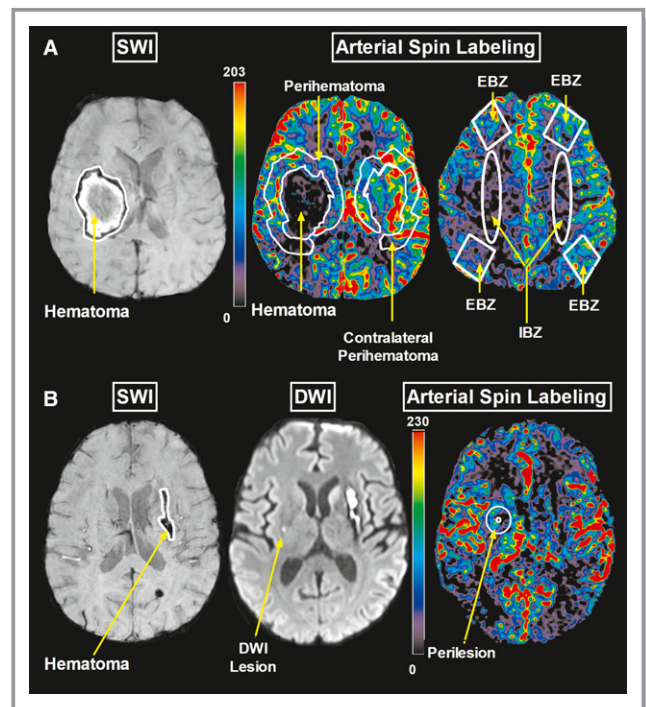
A, The hematoma was delineated using susceptibility-weighted images (SWIs; left), which were then coregistered with arterial spin labeling (ASL) scans (right). Regions of interest included perihematoma, hemisphere, internal and external border zones (IBZs and EBZs, respectively), and the contralateral homologous regions. B, Ischemic lesions were identified with diffusion-weighted imaging (DWI) and coregistered with ASL scans. The area surrounding the ischemic lesion was compared with a homologous contralesional area.
